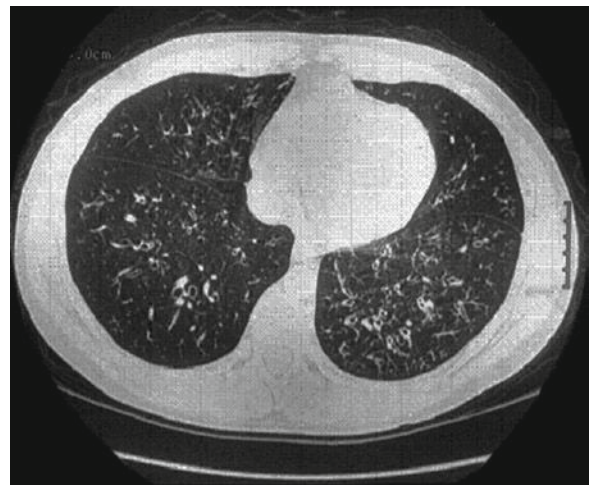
Computed tomography of the chest in a patient with bronchiolitis obliterans showing diffuse areas of parenchymal hypoattenuation, proximal bronchiectasis, and subsegmental bronchial dilatation (Reprinted by permission from Afessa et al. [53], Copyright 2001 Macmillan Publishers Ltd.)
